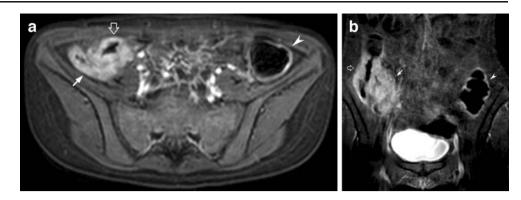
A 16-year-old child with CD. MRI. a, b Axial (a) and coronal (b) gadoliniumenhanced 3-D gradient-echo (THRIVE) images show significant mural thickening with intense contrast enhancement of the terminal ileum (*arrows*) and caecum (*white open arrows*). Marked enhancement of the thickened descending colon is evident (b *arrowheads*)
